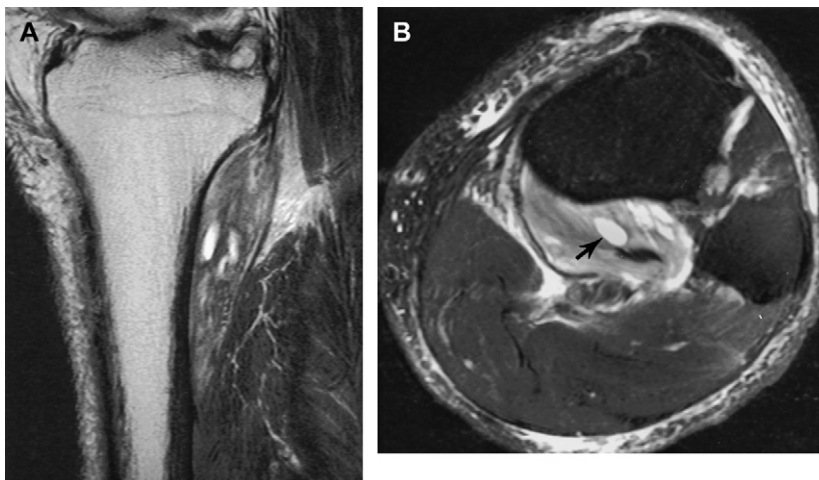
Popliteus muscle tear. Sagittal T1- (A) and axial fat-suppressed fast spin-echo T2-weighted (B) images demonstrate diffuse abnormal signal intensity in the popliteus muscle, with a small central hematoma (arrow in B).
